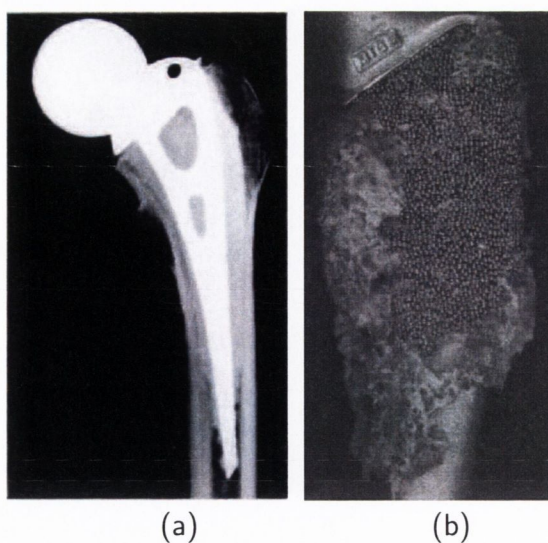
Methods of fixation (a) radiograph of prosthesis fixed by bone cement (Charnely, 1960) (b) prosthesis fixation by bone ingrowth (Eldridge and Learmonth, 1999).
